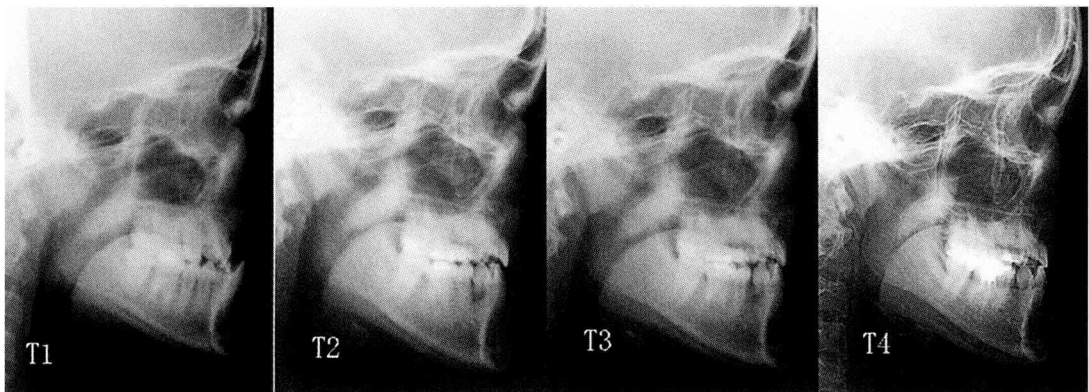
Roentgenographic cephalogram
